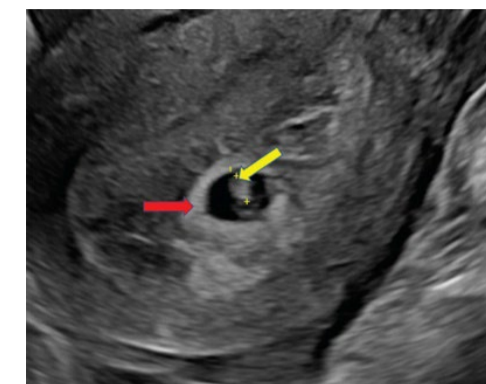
Longitudinal transvaginal ultrasound demonstrates an intrauterine gestational sac (red arrow) with a fetal pole (yellow arrow). Crown rump length measures 0.37 cm which correlates to the gestational age of 5 weeks and 5 days. Fetal heart rate was 126 beats per minute.
